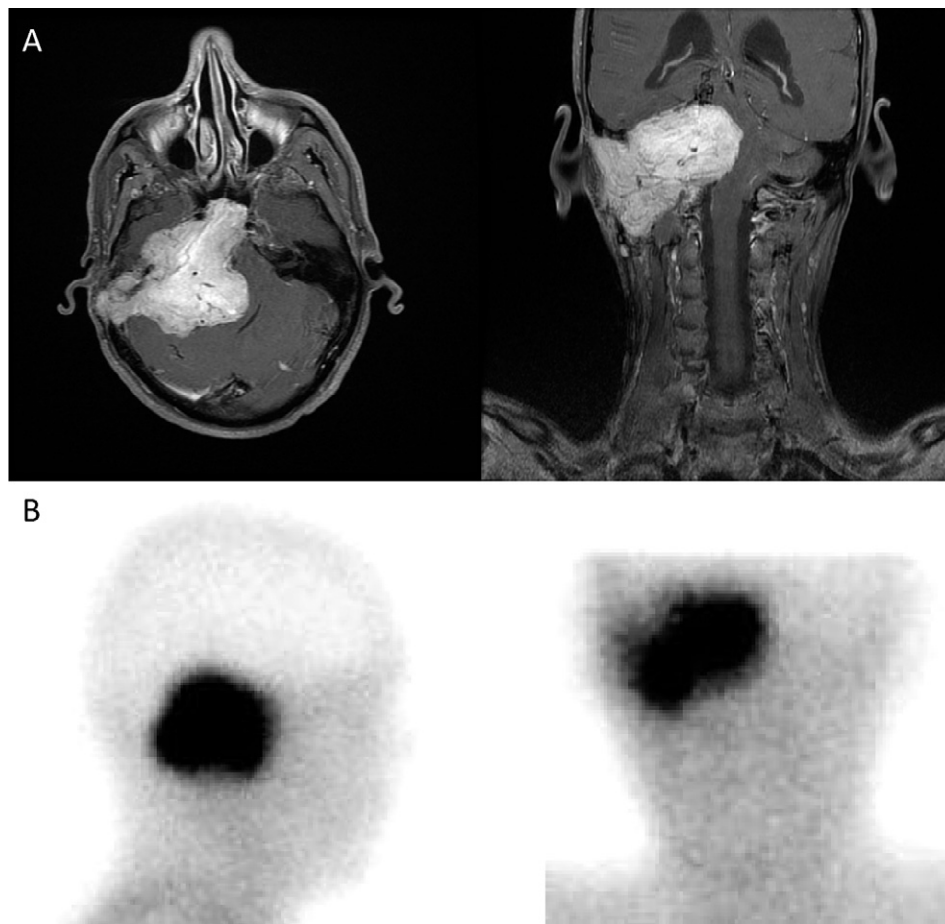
Panel A: cerebral magnetic resonance imaging, T1-weighted, axial and coronal views, showing the tumour with compression of the brain stem and extension to the posterior fossa. Panel B: metaiodobenzylguanidine scintigraphy showing the high fixation of the tumour, consistent with a paraganglioma.
